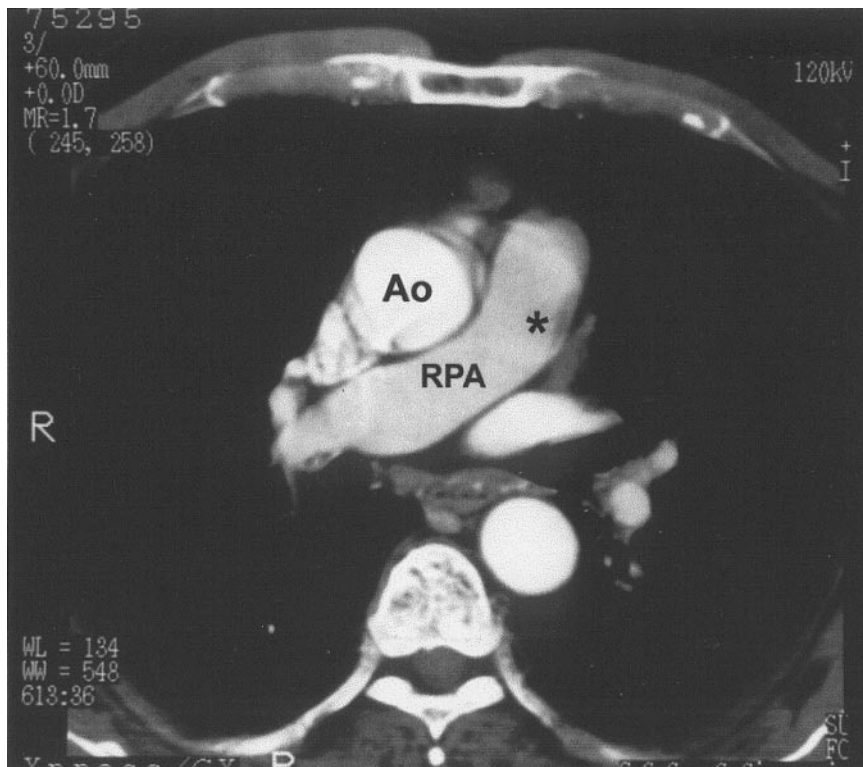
Helical CT scanning in COPD patient with type 2 lesion by TEE presented in Figure 2. A round lesion (*) is evident totally adherent to right pulmonary artery (RPA) wall. Ao indicates aortic root.
